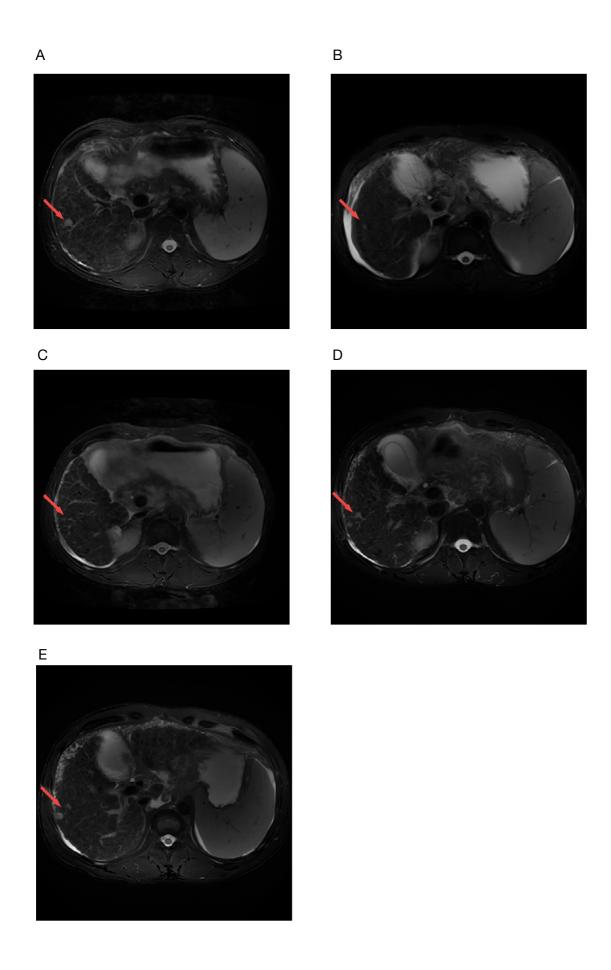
Example HCC false negative cases. i). Hepatocellular adenoma with carcinogenesis. ii), small hepatocellular carcinoma. (A) T2WI (B) DWI (C) Pre-contrast—T1WI (D) late arterial phase (E) portal venous phase (F) equilibrium phase.
